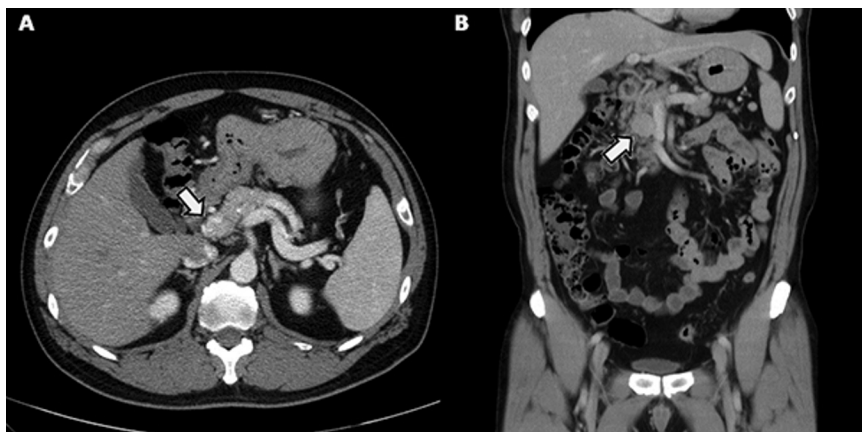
Abdomen CT axial (A) and coronal (B) images showing a 2.7×2.4-cm, lobulated, enhancing lesion at the pancreas head (open arrow).
